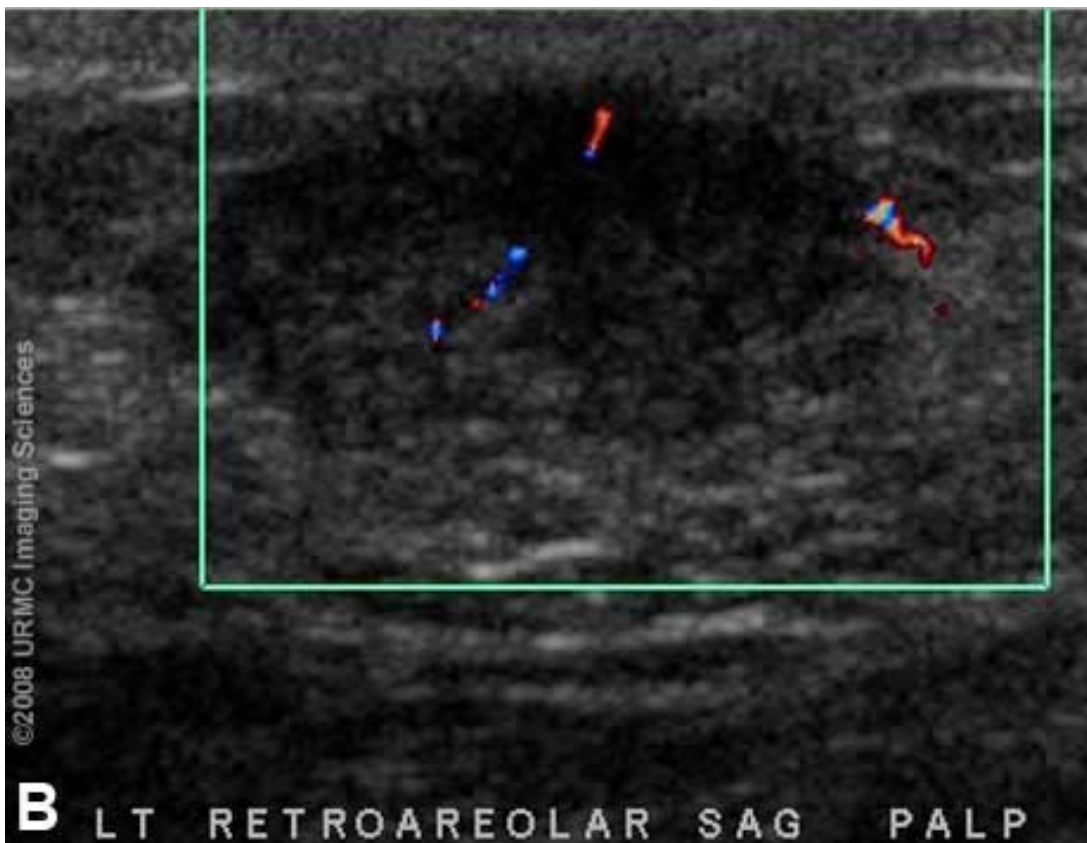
Longitudinal grayscale (A) and color flow Doppler (B) images of the left retroareolar mass demonstrate a lobulated, heterogeneous but predominantly hypoechoic mass with internal vascularity.
